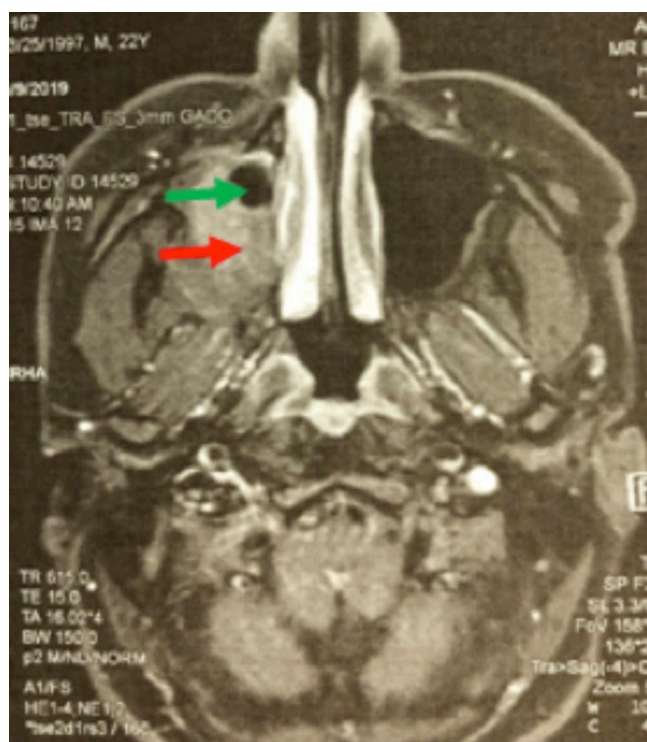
Face MRI axial section, T1 sequence showing hypersignal filling of the right maxillary sinus (red arrow) and the ectopic tooth (green arrow)
